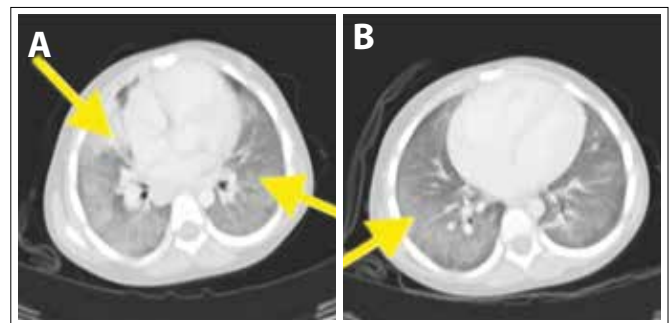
High-resolution computed tomography (HRCT) chest axial views of the patient. A fine reticular pattern and consolidation (yellow arrows) were noted. (Courtesy of Dr D Parris, Department of Paediatrics and Child Health, Steve Biko Academic Hospital)
